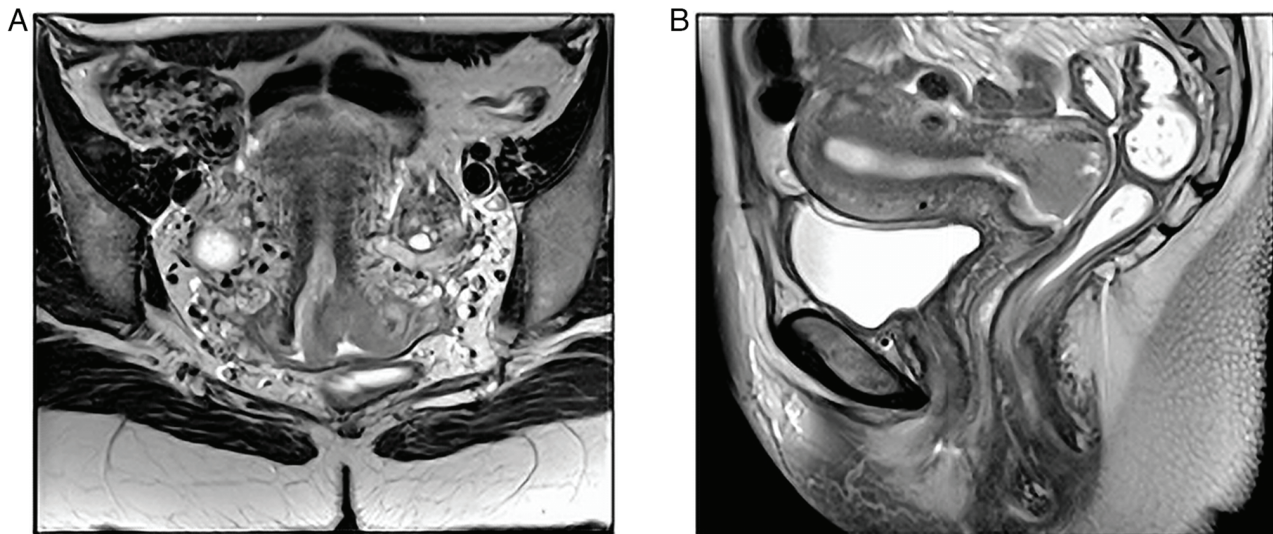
Magnetic resonance imaging. (A) Coronal section: Mass occupying uterine cervix. (B) Sagittal section: Mass in intimal contact with the vaginal posterior wall.
